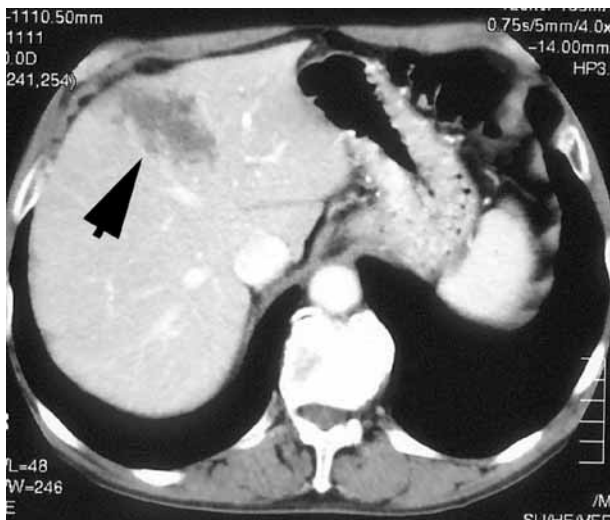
Computed tomography of the liver (case 1) ; showing hepatic segment IV infection by *E. multilocaris*.
